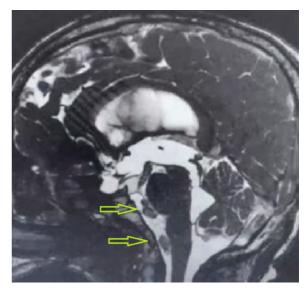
Sagittal MRI of the skull in Fiesta sequence showing thin-walled vesicular lesions associated with racemose neurocysticercosis.
